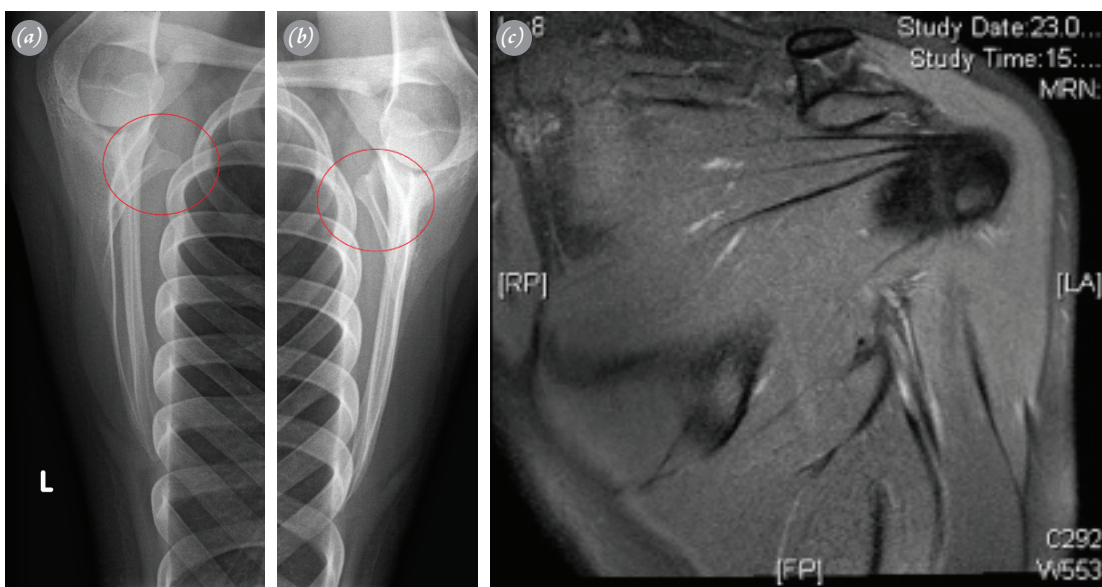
(a, b) Initial scapular target radiographs of both sides. Significant prominence of the superomedial scapula (red circle). (c) MRI of the left shoulder (coronal view): evidence of bursitis and fluid accumulation in the glenohumeral tissue at the superomedial border of the scapula.
